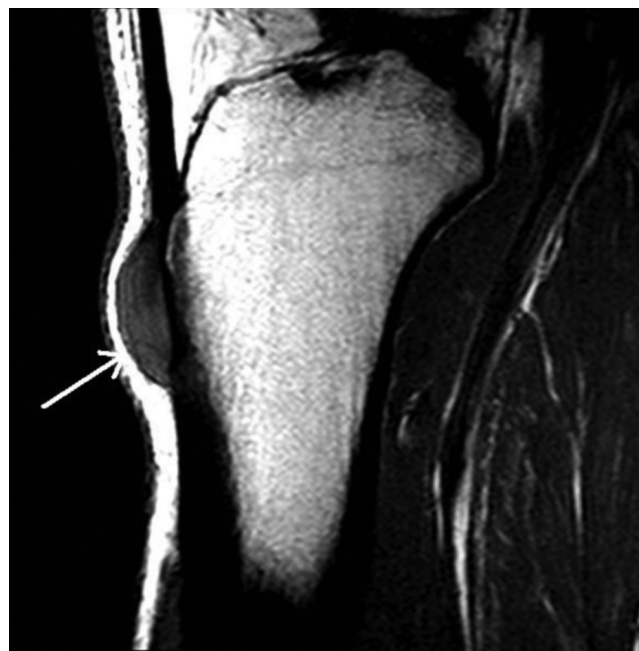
38-year-old man with multiple tendon xanthomatosis. Top: Sagittal T1-weighted MRI shows a pretibial lesion (arrow) at the level of the tibial tuberosity at and inferior to the distal insertion of the patellar tendon, with similar signal characteristics to the finger lesion. The patellar tendon appears normal. Above: Sagittal T2-weighted fat-suppressed MRI shows the lesion to be low in signal (arrows).
